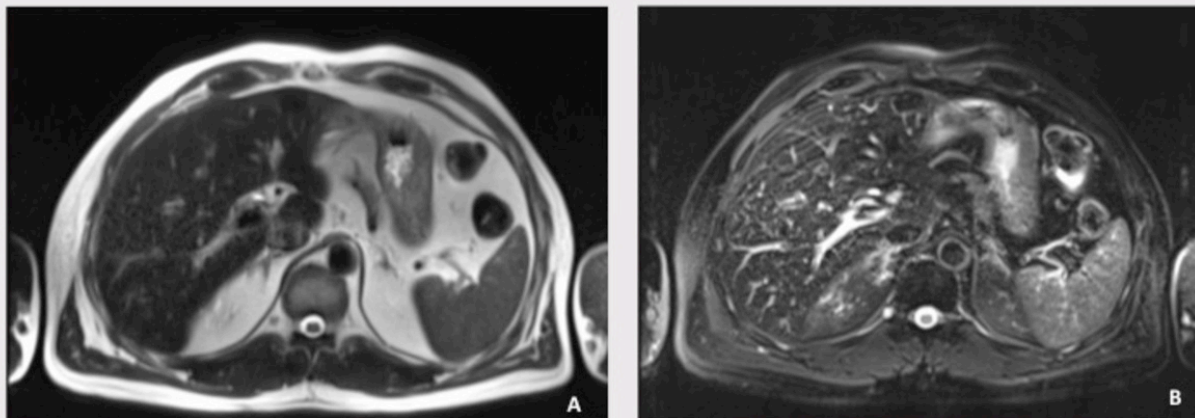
On a T2-weighted MR images (A, B), the pigmented hepatocellular adenoma with intralesional siderosis shows marked hyperintensity relative to the background liver.
